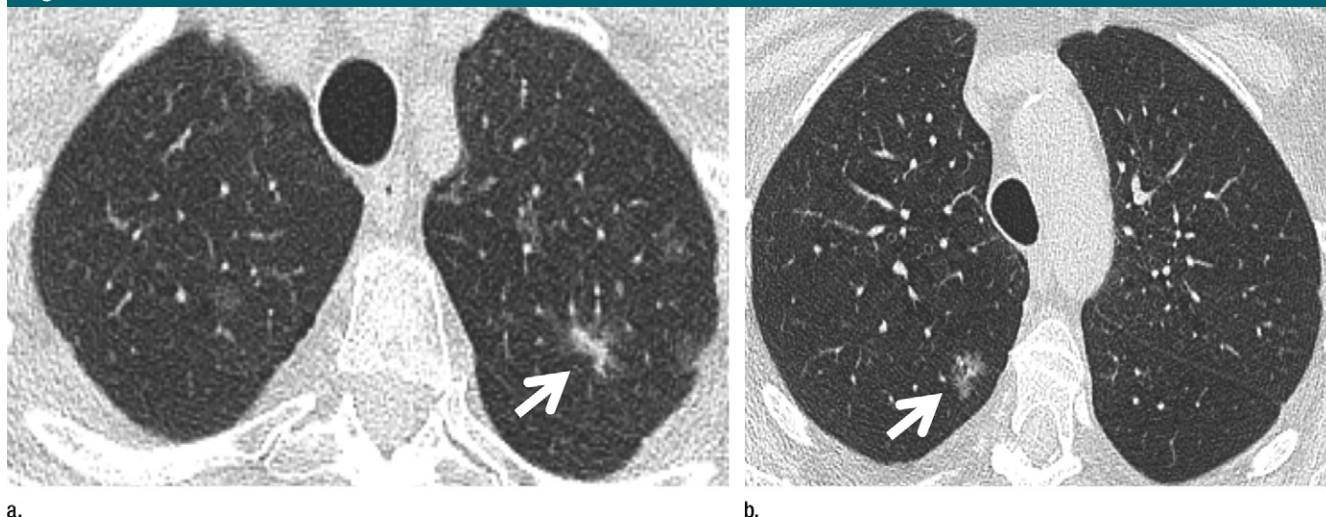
(a) Transverse 1-mm CT section through the upper lobes shows multiple variable-sized subsolid nodules bilaterally, including at least one highly suspicious (large size, ground-glass appearance, and solid morphology) part-solid lesion in the left upper lobe (arrow). Initial follow-up would be appropriate in 3–6 months. (b) A more inferior section from the same examination shows another highly suspicious lobulated 10-mm ground-glass nodule in the right upper lobe (arrow), which would also warrant follow up. The findings are most consistent with multifocal primary adenocarcinoma.
